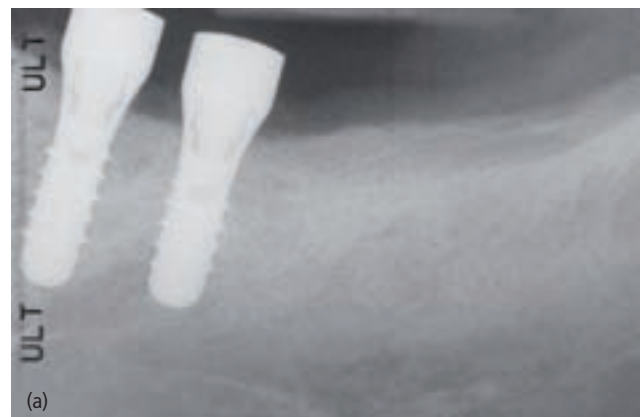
Angulation of X-rays can provide misleading information. (a) Initial radiograph gives the appearance at sites 20 and 21 that there was pronation of the wrist upon implant insertion. (b) Corrected angulation of radiograph indicated that the implants were placed straight.
